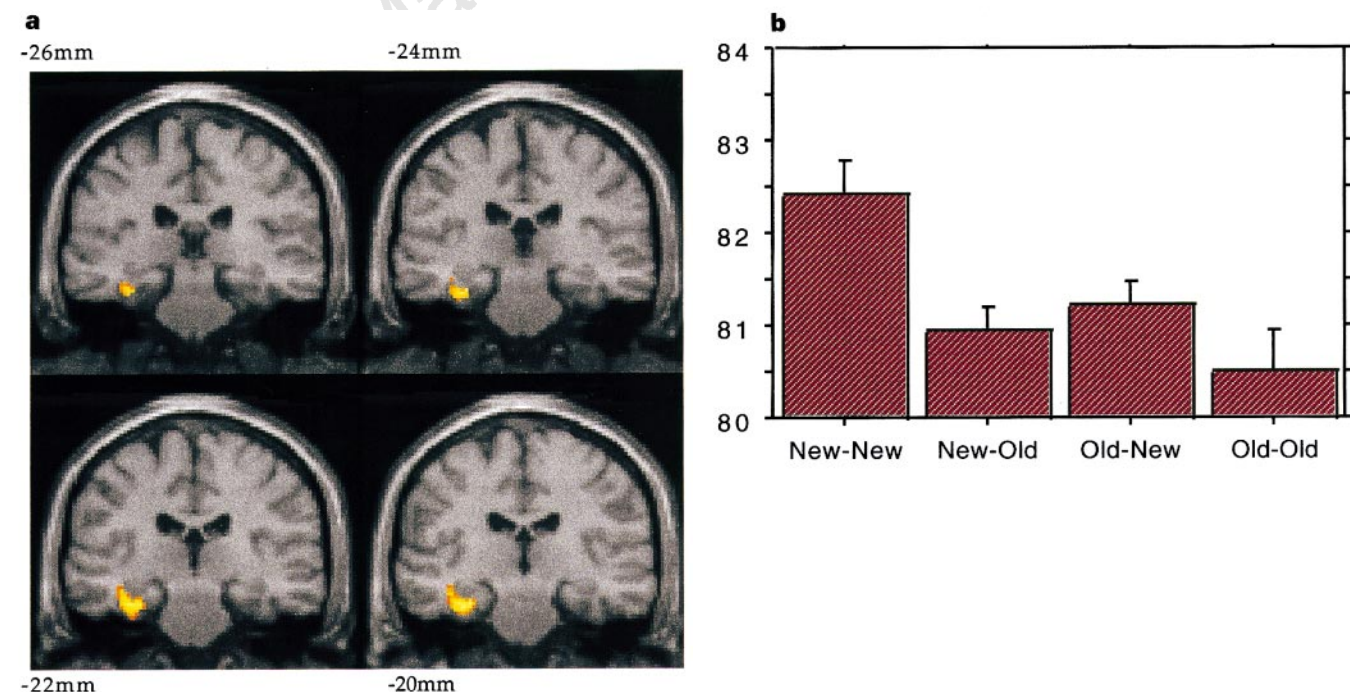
a, An SPM of the comparison between the 'new-new' and the 'old-old' conditions, showing significantly greater activation in the former centred on the left medial temporal cortex that incorporates the left hippocampus. The SPM has been superimposed onto 4 consecutive coronal MRI sections in the y-axis, progressing in 2-mm increments from 24 mm (top left section) to 18 mm (bottom right section) posterior to the anterior commissure. b, Regional cerebral blood flow equivalents (together with standard error bars) from one of the two most
